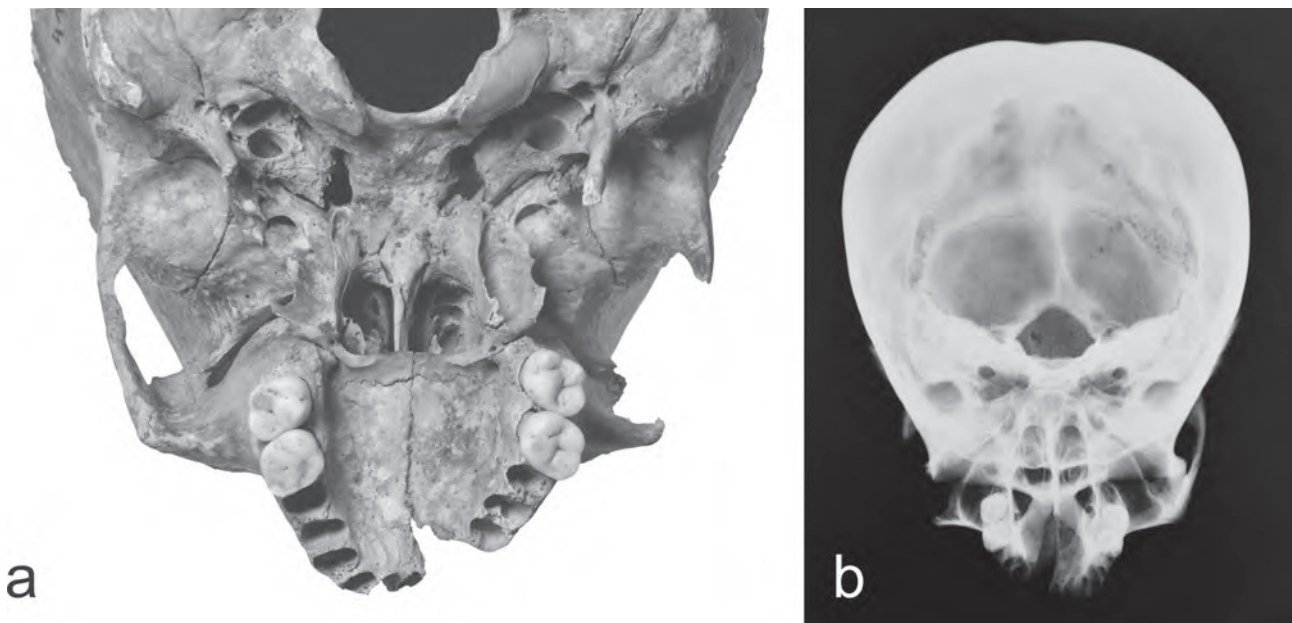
a) Detail of traumatic defect of maxillary alveolar complex (basal view); b) X-ray (K 417, Křtiny, Czech Republic, 13th–18th century). Photo by J. Vachová.
